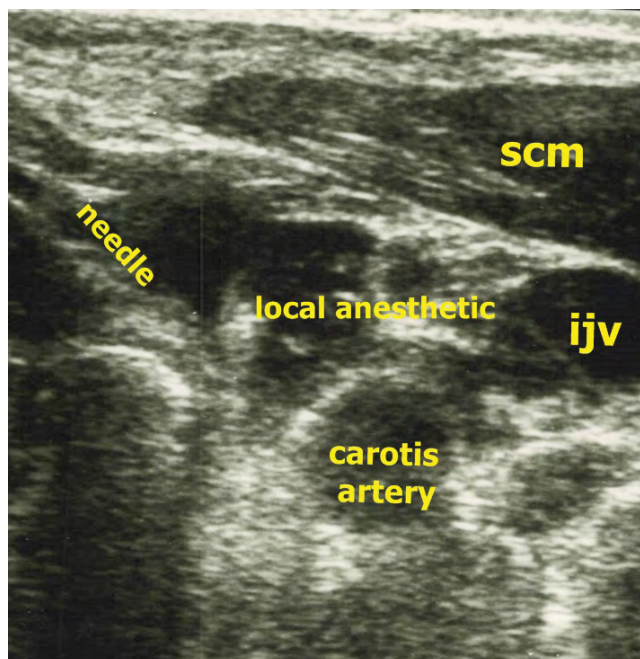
Sonographic anatomy, needle direction, and spread of local anesthetic around the carotid artery.
